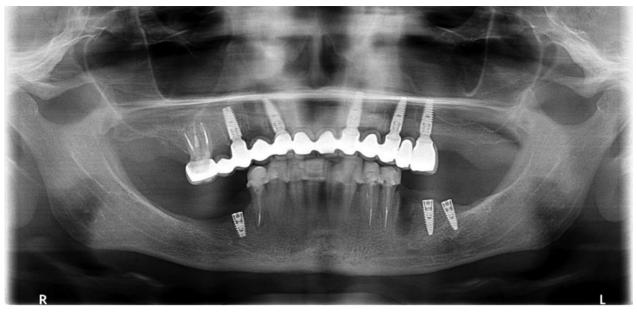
Panoramic x-ray with temporary upper bridge and implants in lower jaw Rycina 9. Zdjęcie radiologiczne panoramiczne z tymczasowym mostem w szczęce oraz wszczepione implanty w żuchwie
